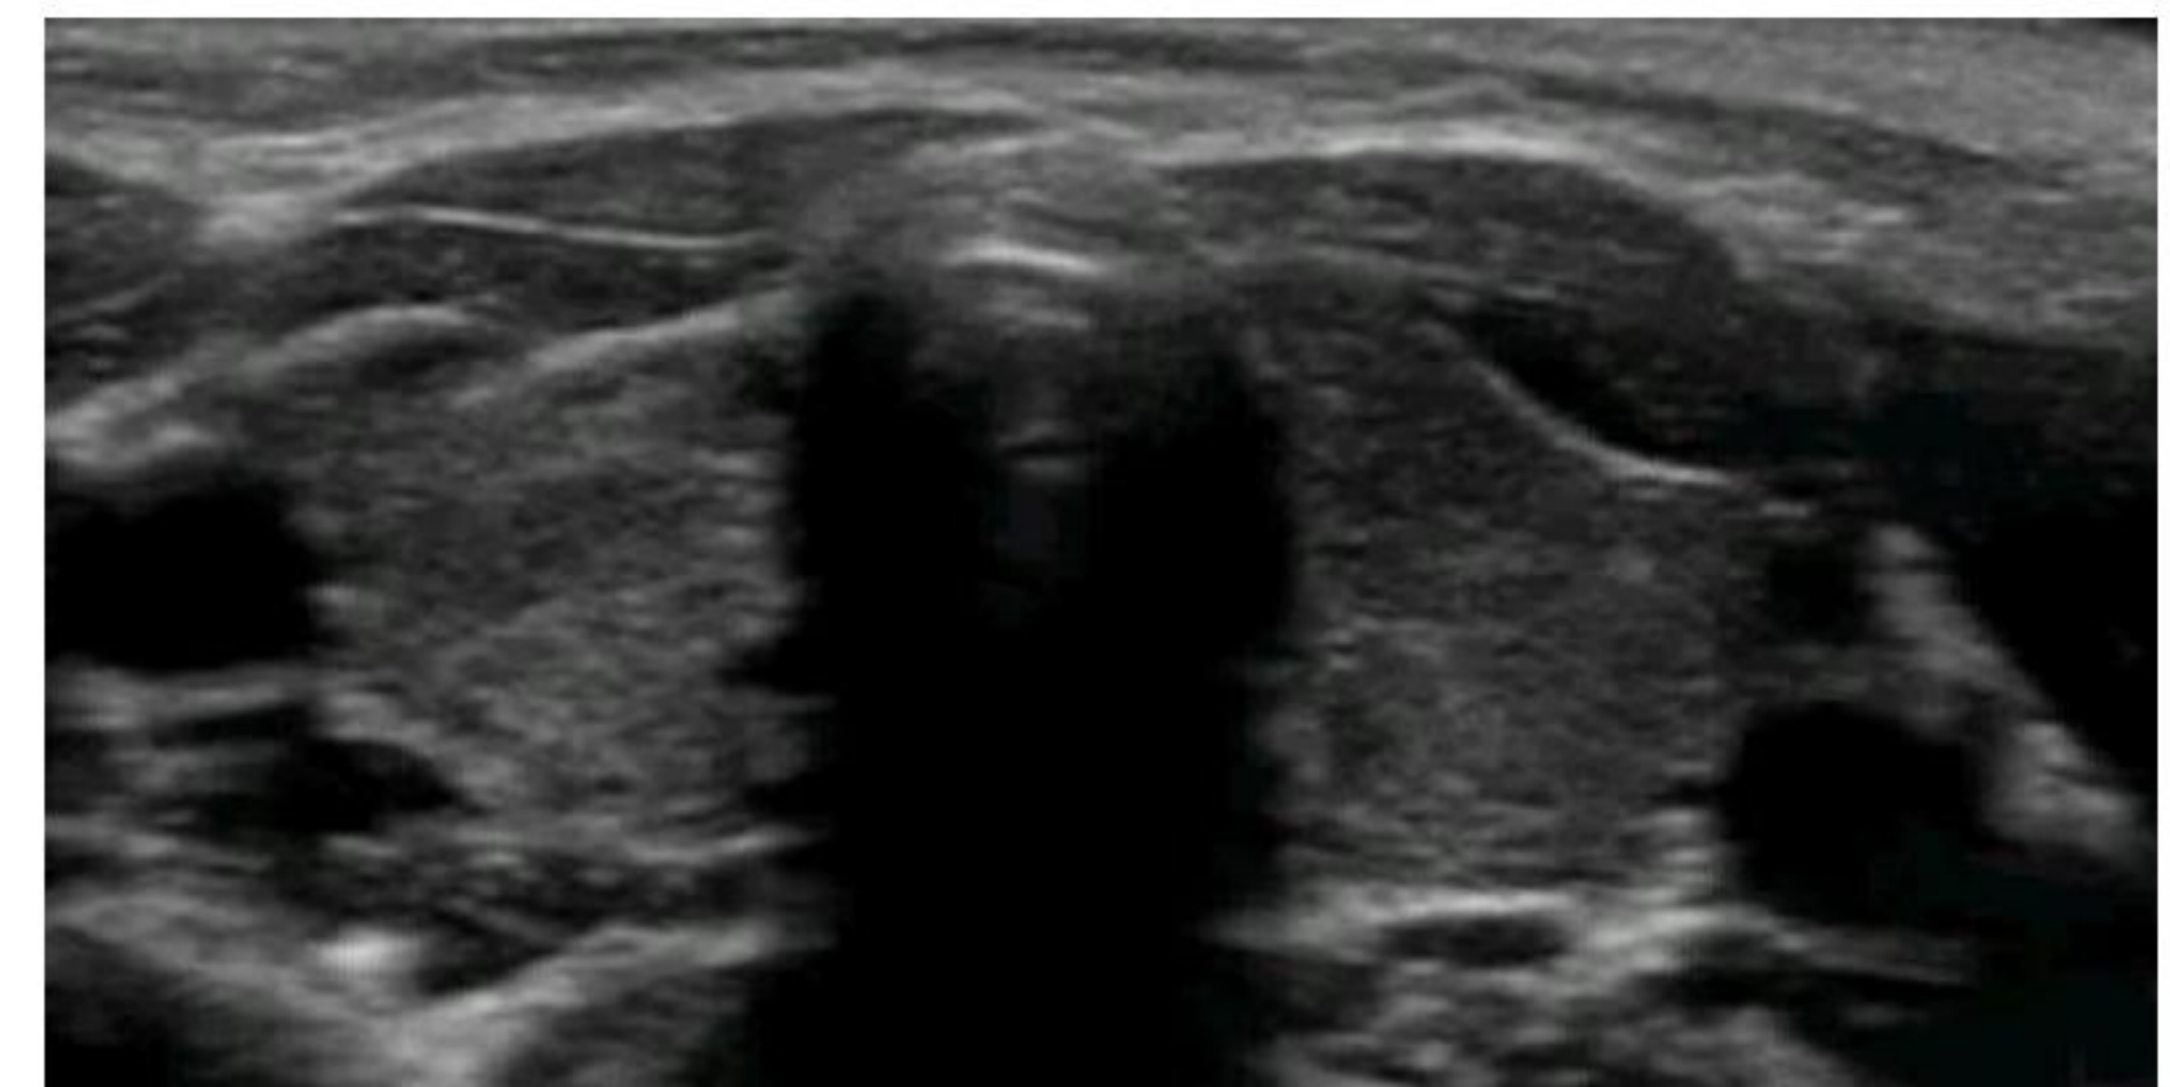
Thyroid ultrasound evaluation: three grade according Sostre classification.
